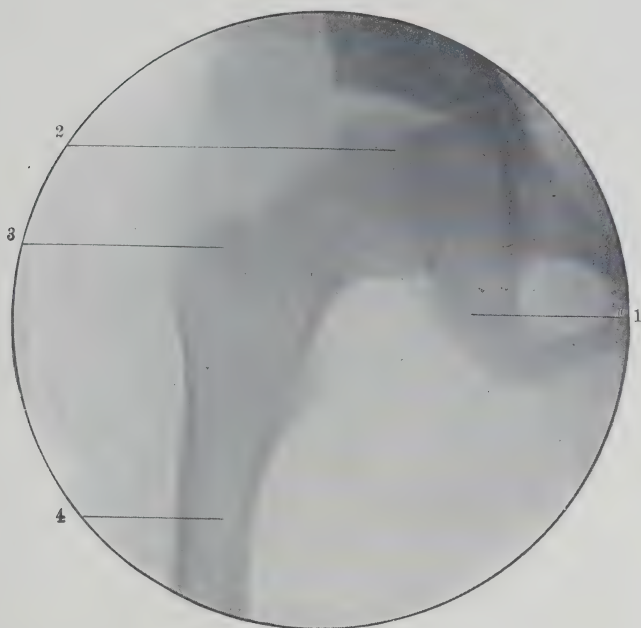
Radiograph Showing Hip Joint at Seven Years. 1, Ischium; 2, head of femur; 3, centre of greater trochanter; 4, femur. (Original.)
